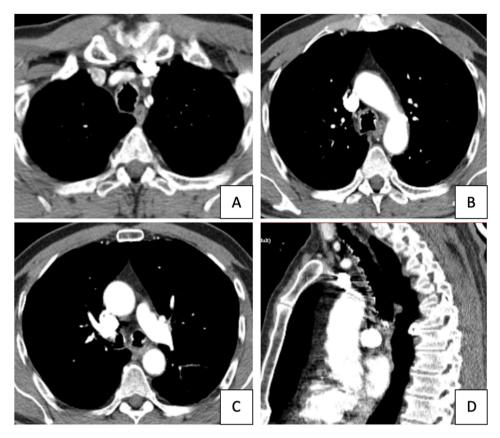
Thoracic CT with contrast revealed Fig. 1A. Narrowing of proximal trachea with multi-nodular calcifications, Fig. 1B. Narrowing of distal trachea with multi-nodular calcifications, Fig. 1C. Narrowing of proximal main bronchi with multi-nodular calcifications Fig. 1D. Multiple calcific protuberations on the anterior wall of trachea.
